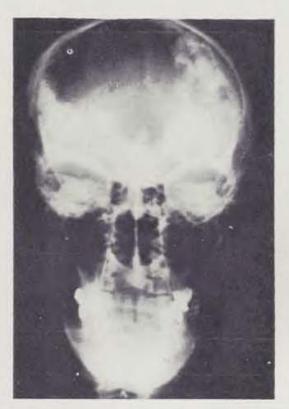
3 AP and lateral X-ray projections of the skull showing the bone defect extent extent
